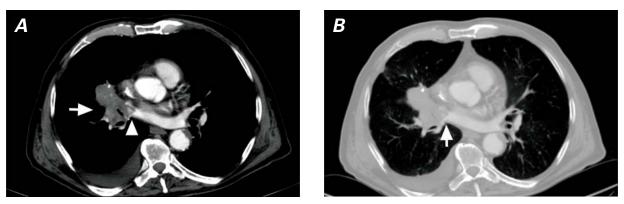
Computed tomographic angiography shows A) a lung mass (arrow) adhering to the right pulmonary artery and infiltrating the right lower pulmonary vein (arrowhead), and B) a 3×2 -cm right-lower-lobe lung mass (arrow) (lung parenchymal window settings).
